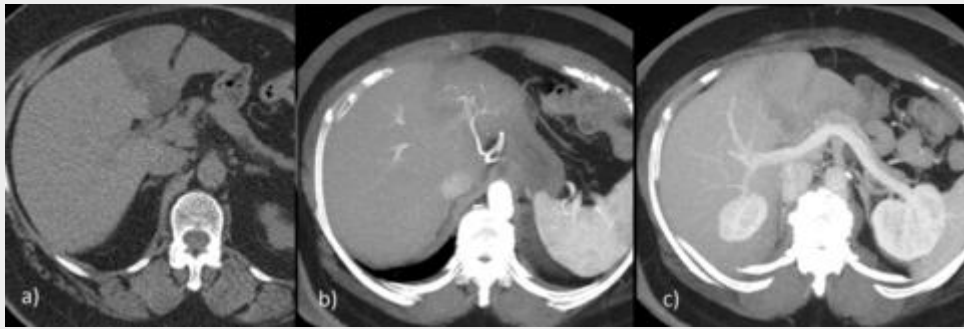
CT axial image (a) and MIP reconstructions (b and c) showing a segmental fat infiltration distribution. In non-enhanced image there is diffuse low attenuation in the left lobe (a), post contrast in late arterial (b) and portal phase (c) reveal an increase in arterial flow by left gastric artery branches (b) and no left portal venous flow (c).
